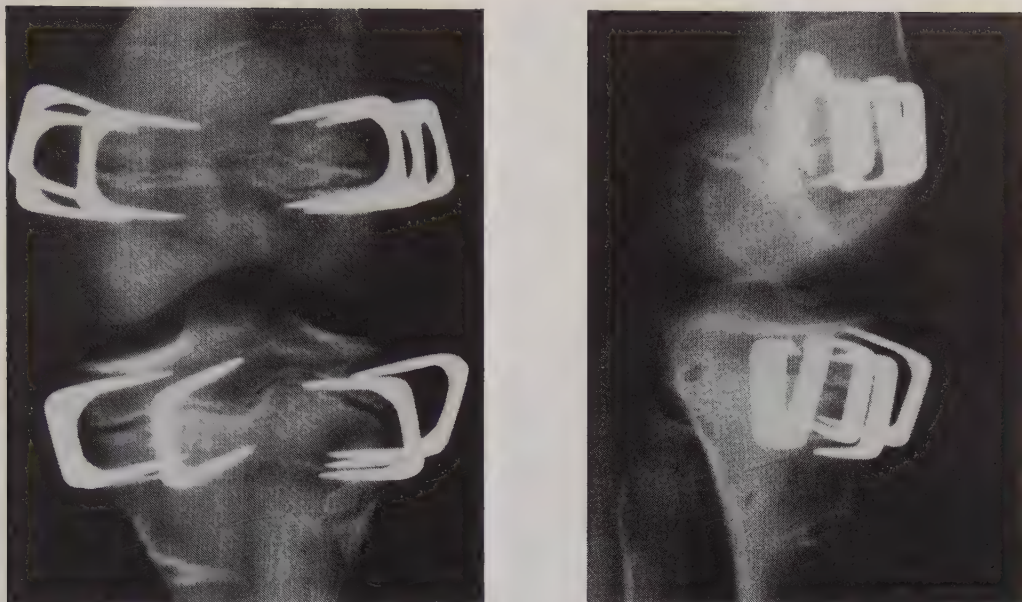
a and b. Case 2. Standard radiographs of left knee at time of extraction of staples in proximal tibia. a) AP view; b) lateral view.
